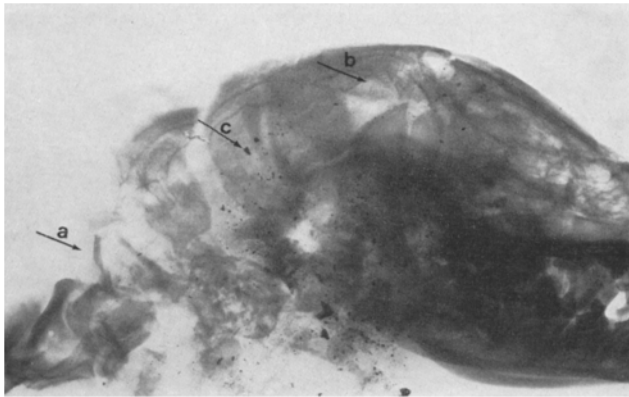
Ammunition type 3. Lateral, dextral radiograph. Neurocranium demolished after a central hit. Wide occipital sutural diastasis. Posterior part of the mandible and the atlas (*a*) fractured. Abundant intra- and extra-cranial bone fragments (*b*) and metal fragments (*c*)
